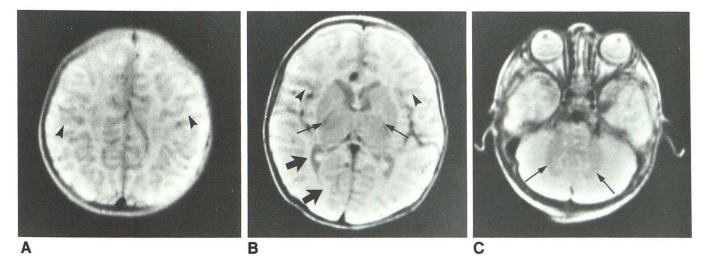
Infantile pattern in 3-month-old boy. Axial MR images (SE 2000/84).
